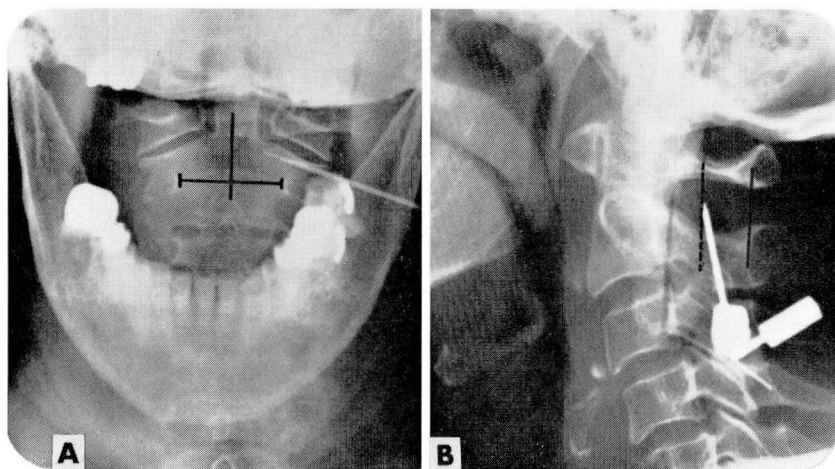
Roentgenograms of the upper cervical level show the needle electrode inserted between the posterior arch of the first cervical vertebra and the lamina of the second cervical vertebra into the anterolateral quadrant of the spinal cord.
